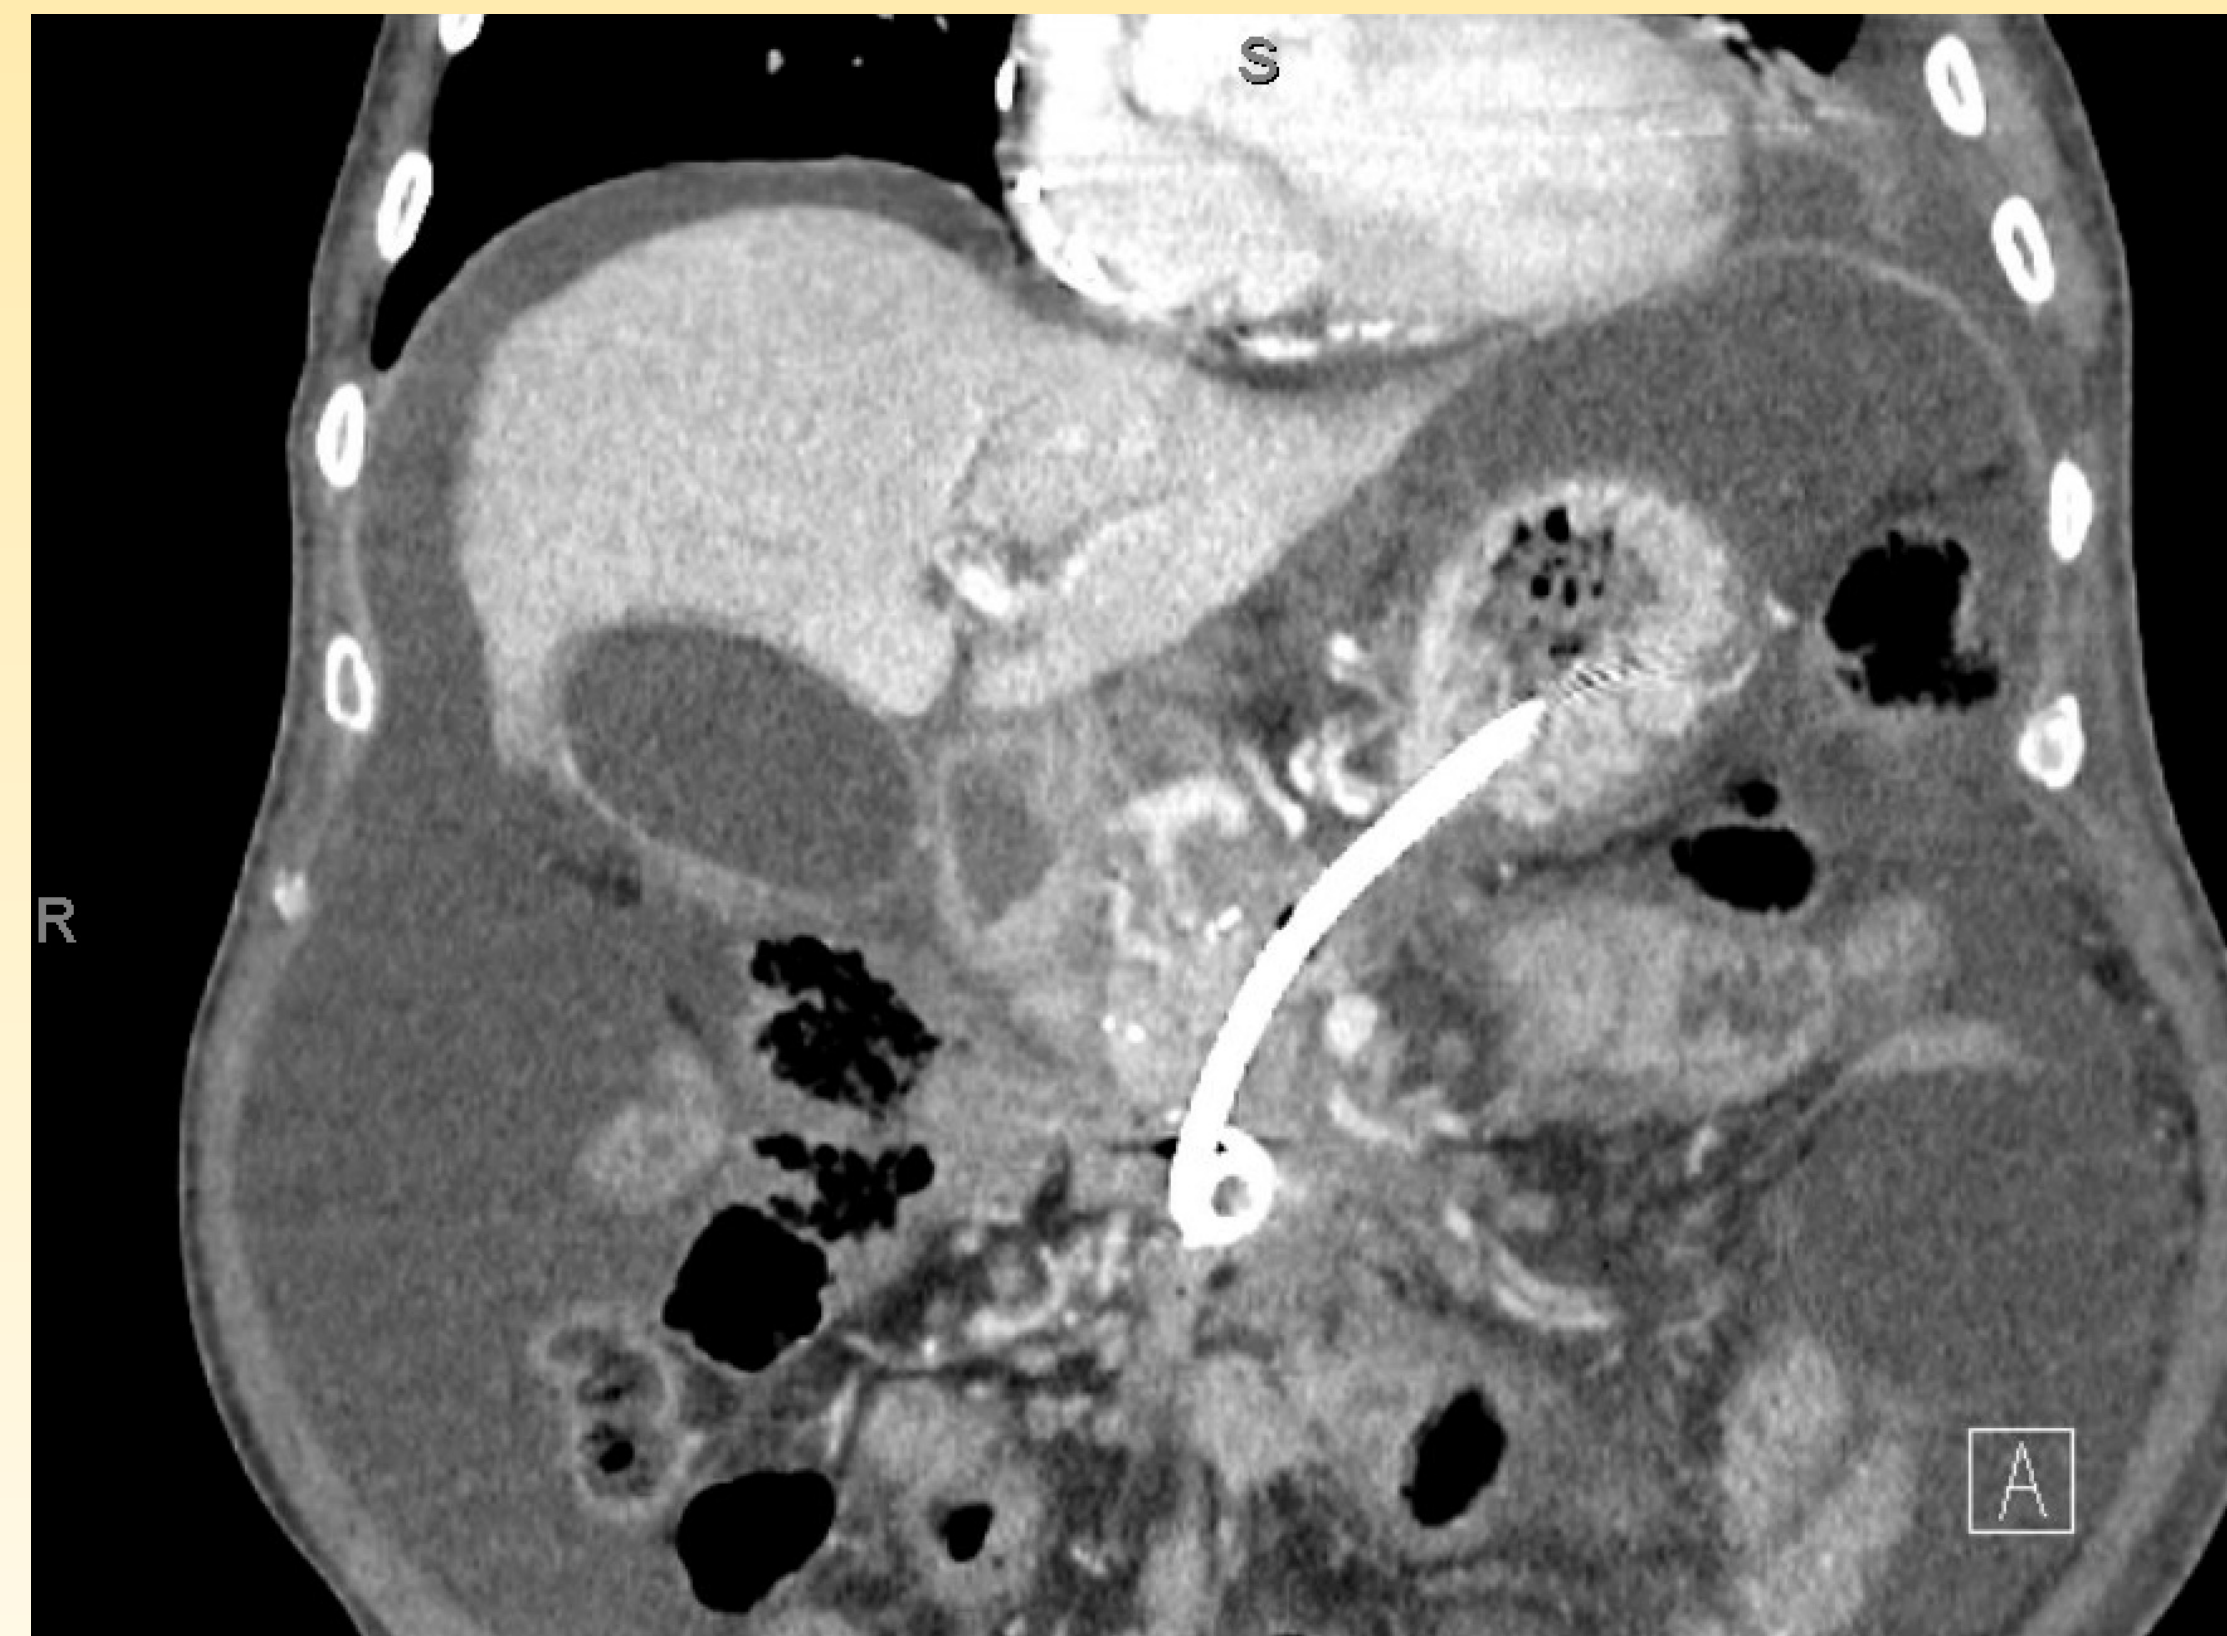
A) Patient A - CT scan with a large amount of chylous ascites (arrow), pancreatic WON with stent placed.
